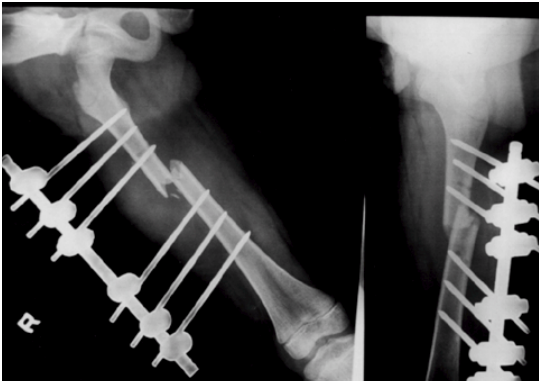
AP and lateral radiographs after external fixation. Reduction and stabilization obtained with AO external fixator.
